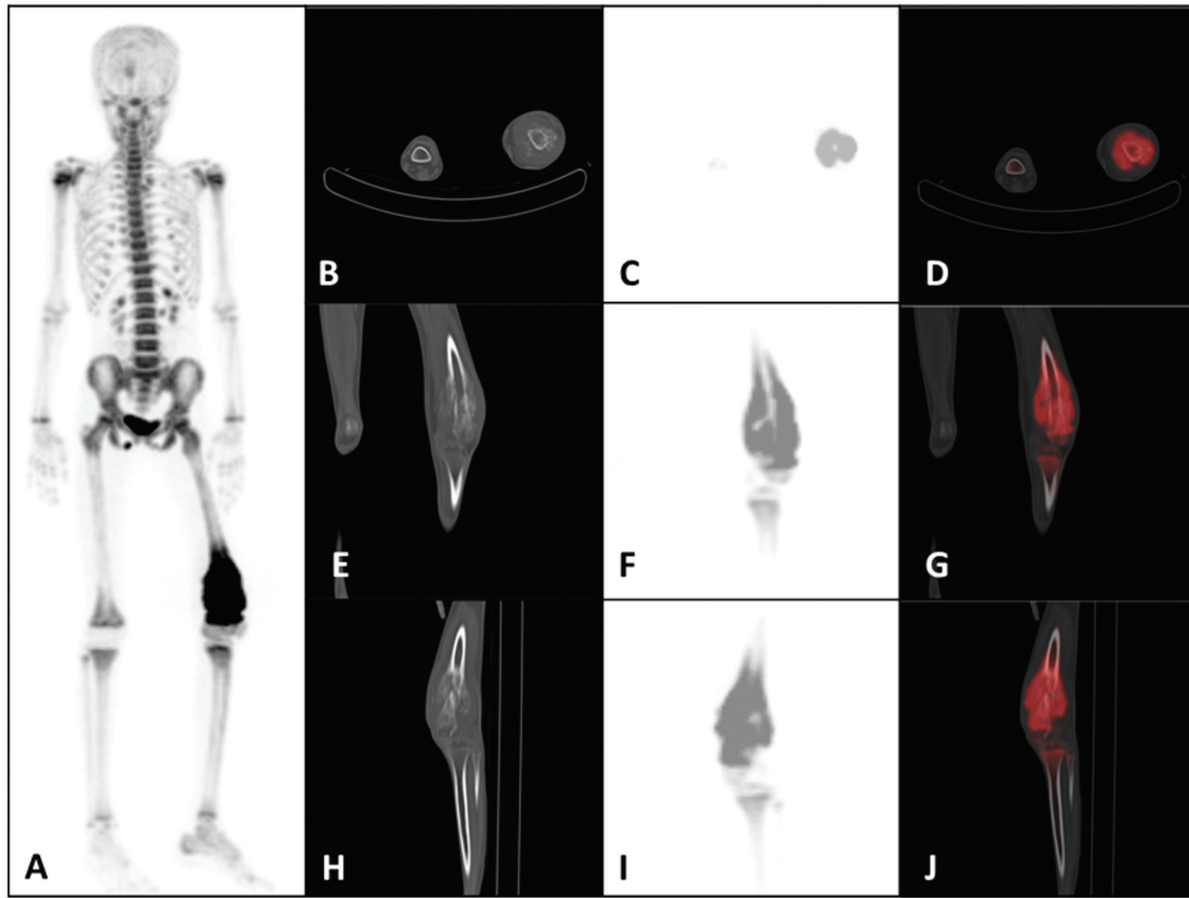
(A) Anterior maximum intensity projection (MIP) of whole-body ^{18}F -sodium fluoride (^{18}F -NaF) positron emission tomography (PET). Noncontrast computed tomography (CT; bone window), PET, and fused PET/CT: (B–D) axial, (E–G) coronal, and (H–J) sagittal images showing increased tracer uptake noted in the site of the primary bone tumor involving the left distal femur (maximum standardized uptake value [SUV_{max}] measuring 10.98).
